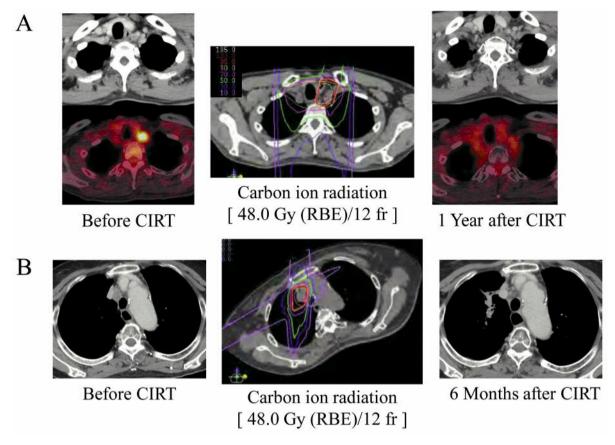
A: Computed tomography (CT) scan and positron-emission tomography (PET) imaging of the first case treated before and after treatment. The middle figure shows the dose distribution. The initial target volume was defined as the lymph node recurrence and the nodal region. After a total dose of 36 Gy, the field was limited to only the macroscopic lesions with an added margin of 1.0 cm. B: CT scan and PET imaging of the patient, who was previously irradiated, before and after treatment. The middle figure shows the dose distribution. Local fields with a margin of 1.0 cm around the macroscopic tumor were used.
